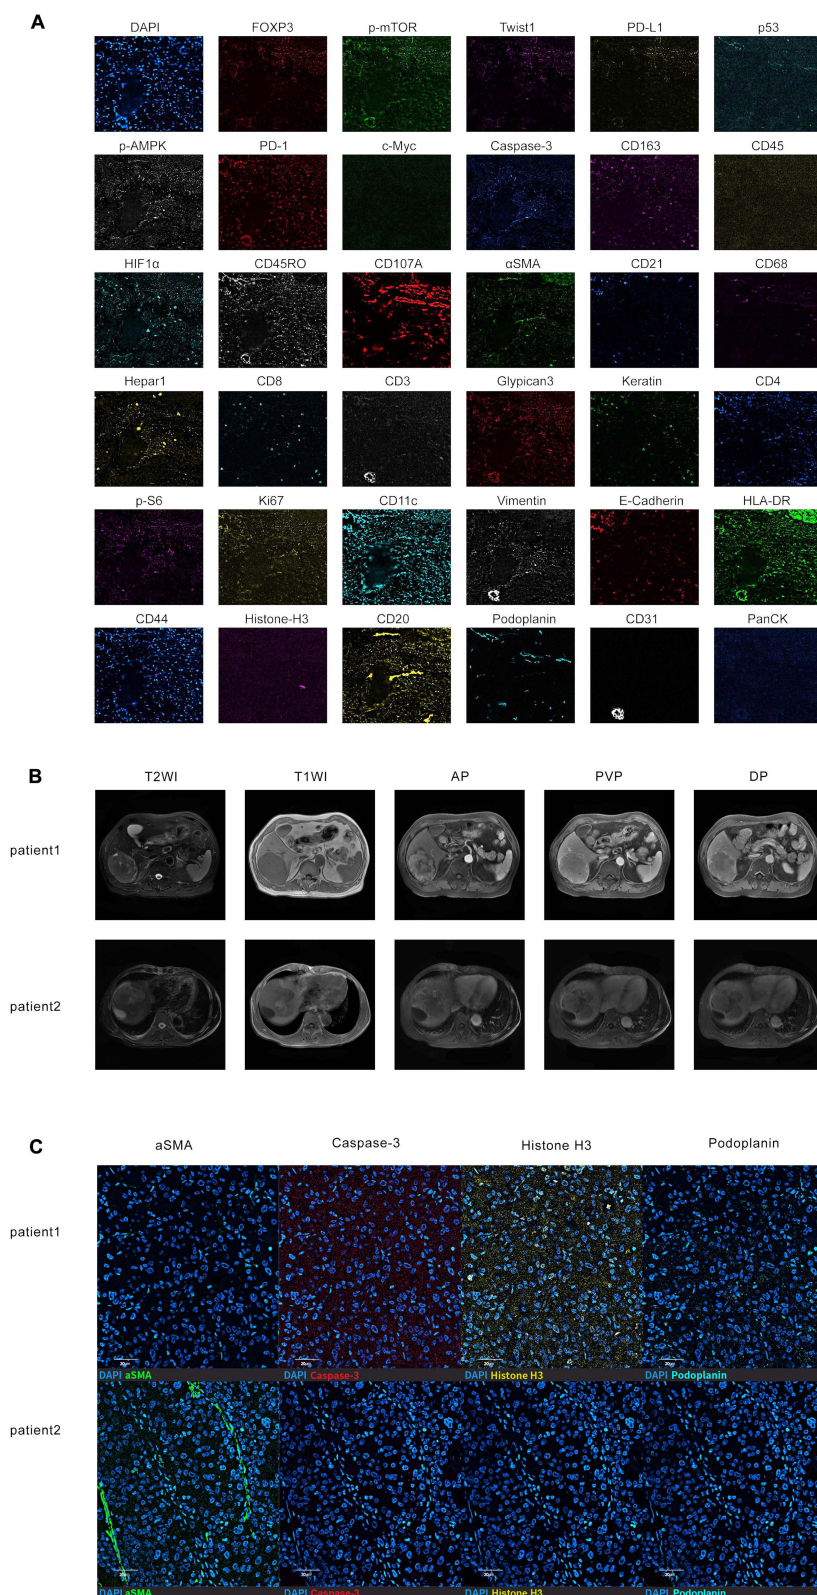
Images of a single tissue region colored for each antibody. Scale bar, 10 μ m (A). Representative HCC patients with their MRI images and CODEX images (B and C). MRI images of T2WI-FS, T1WI, AP, PVP, and DP for these patients (B). CODEX images of four proteins (α -SMA, Caspase-3, Histone H3, and Podoplanin) in these patients (C). Patient 1: male, tumor maximum diameter of 8.0 cm, died at 25 months, exhibited high levels of Caspase-3 and Histone H3, and low levels of α -SMA and Podoplanin. Patient 2: male, tumor maximum diameter of 7.6 cm, alive at 60 months, exhibited low levels of Caspase-3 and Histone H3, and high levels of α -SMA and Podoplanin.
